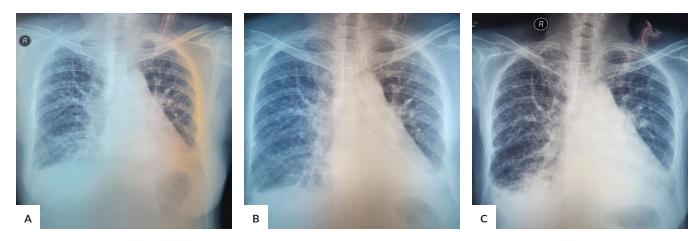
Representative chest radiographs were taken at different time points throughout the patient's course. (A) 2018. The interstitial lung markings are thickened. The heart is enlarged. Both costophrenic sulci are blunted obscuring both hemidiaphragms. Images in (B) 2019 and (C) 2021 are unchanged from 2018.
